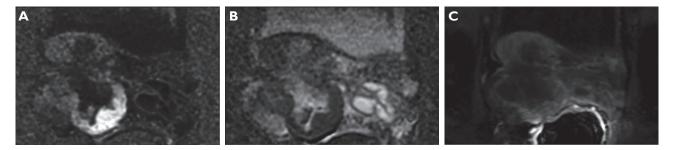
1.5 magnetic resonance imaging: axial diffusion weighted imaging (A) and apparent diffusion coefficient map (B) image showed the presence of areas of diffusive restriction; axial post-contrast (C) image showed a peripherical enhancement surrounding the necrotic/ colliquative central areas.
